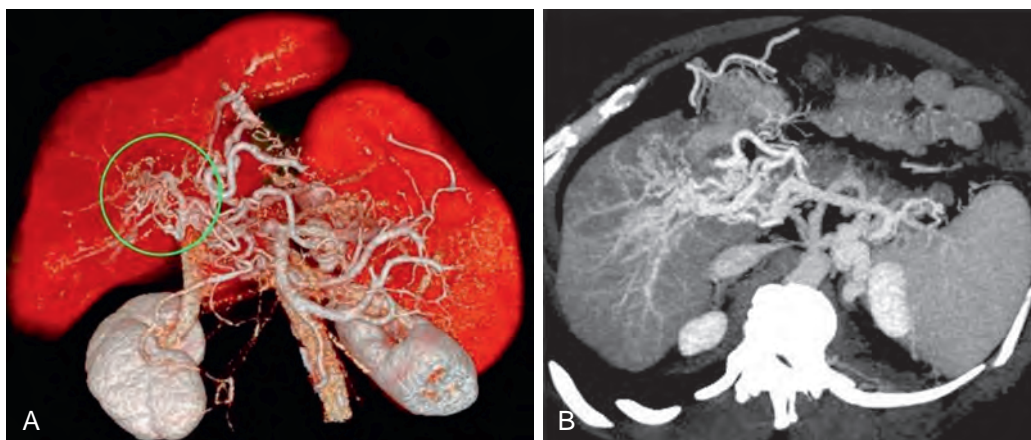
Cavernous transformation of the portal vein: CT features. Three-dimensional shaded surface coronal (A) and axial (B) MDCT images show multiple enhancing tubular structures (circle) in the hepatoduodenal ligament.
